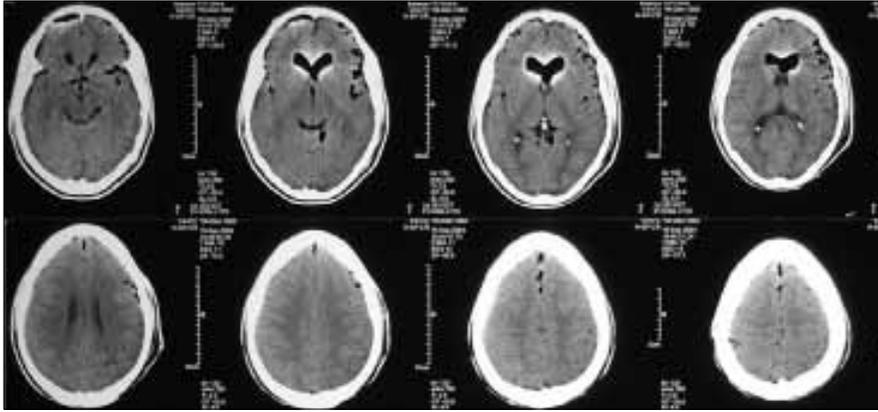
CT scan of brain showing extensive pneumocephalus. Parietal slice (lower left) reveals extensive soft tissue swelling and break in the skin where the bullet tangentially traversed the soft tissue, without underlying bony fracture.
